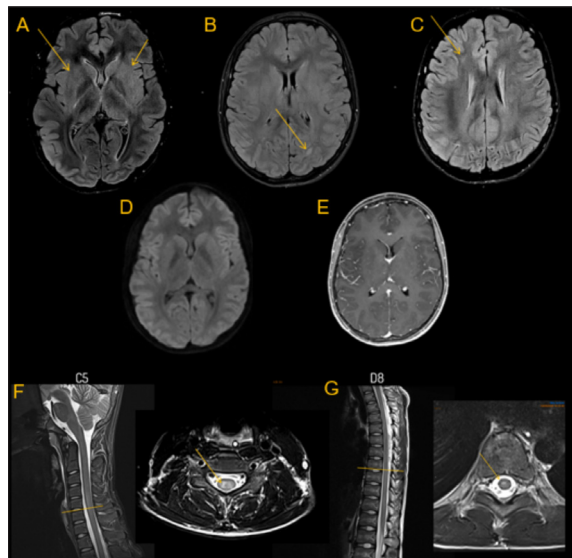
Axial T2 FLAIR (A-C); Axial DWI (D); axial T1 after gadolinium (E); Axial and sagittal T2 images (F-G). Involvement of the basal ganglia (arrows on A) and bilateral subcortical white matter is observed. Two focal lesions are slightly more evident in T2 and T2/FLAIR sequences: one in the left parieto-occipital juxtacortical region (arrow on B) and another in the right subcortical frontal white matter (arrow on C), without diffusion restriction or contrast enhancement. The spinal cord shows subtle, ill-defined T2 hyperintensities at the C5-C6 and D8-D12 levels, without mass effect or contrast enhancement. These findings suggest ADEM.
